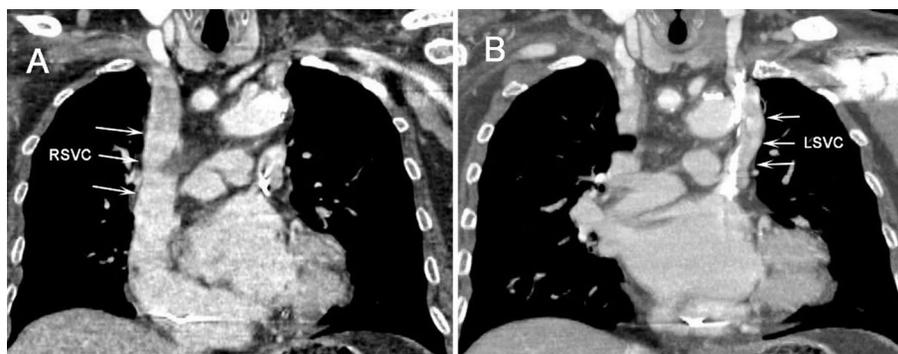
Double superior vena cava; female, 80 years old; a computed tomography (CT) scan showing the location of the vessel with respect to surrounding thoracic organs; A. A frontal cross-sectional CT view of the right superior vena cava (RSVC) and its drainage into the right atrium; B. A CT scan showing the presence of the left superior vena cava (LSVC) and an absence of the brachiocephalic vein.
